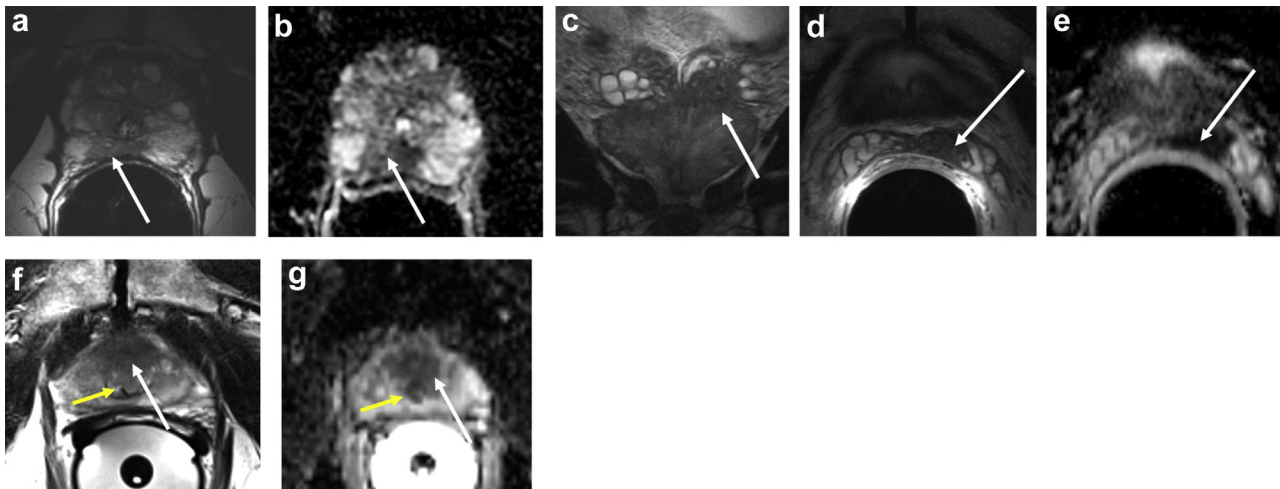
Prostate cancer tumor extension delineated on MRI. (a) and (b): axial T2-weighted images (a) and apparent diffusion coefficient (ADC) maps (b) of the prostate demonstrate an area of T2 hypointensity and restricted diffusion centered within the right peripheral zone at the level of the midgland, consistent with organ confined disease (white arrows). (c)–(e): coronal (c) and axial (d) T2-weighted images and axial ADC maps (e) of the prostate and seminal vesicles demonstrate T2 hypointense diffuse tumor involving the right and left gland from apex to base, including extracapsular extension and left seminal vesicle invasion (white arrows). (f) and (g): axial T2-weighted images (f) and ADC maps (g) of the prostate demonstrate an area of T2 hypointensity and restricted diffusion within the anterior peripheral zone, consistent with distal apical tumor (white arrows) with urethral involvement (yellow arrow).
